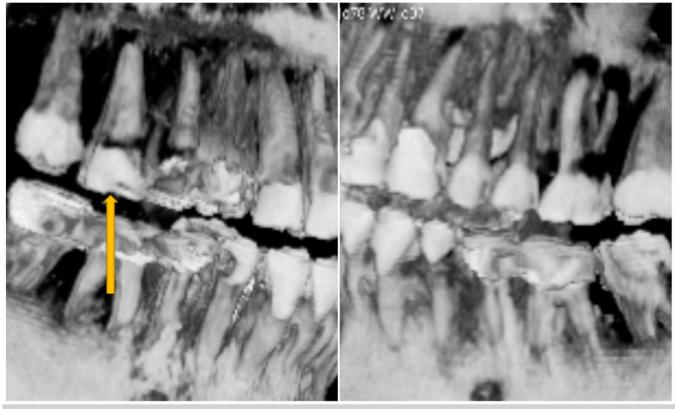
3D CBCT View; right & left showing the right upper 1st molar with one root on buccal aspect (arrow) while left upper 1st molar with two roots on buccal aspect.
